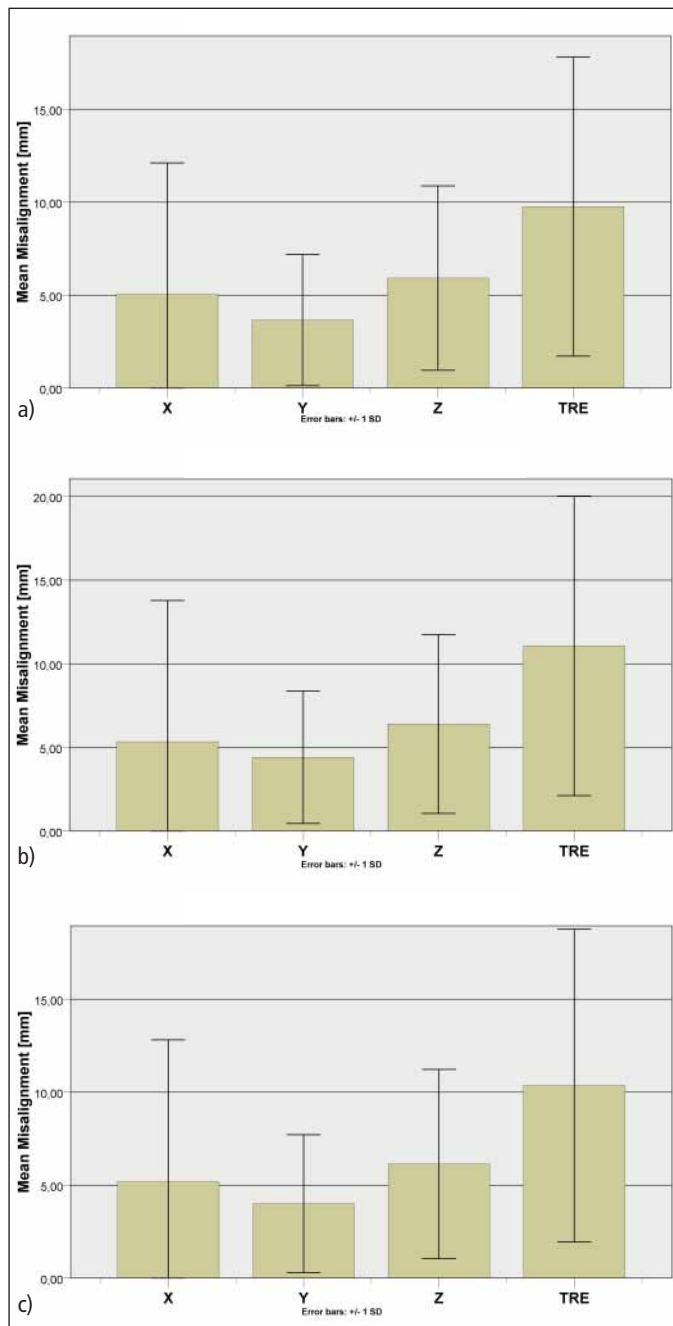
Average misalignment and standard deviation (black bars) of abdominal lesions after retrospective registration measured in total as well as in 3 orthogonal directions a) FDG-PET and T1-weighted MRI datasets b) FDG-PET and T2-weighted MRI datasets c) FDG-PET and MRI (T1 & T2 pooled) datasets
